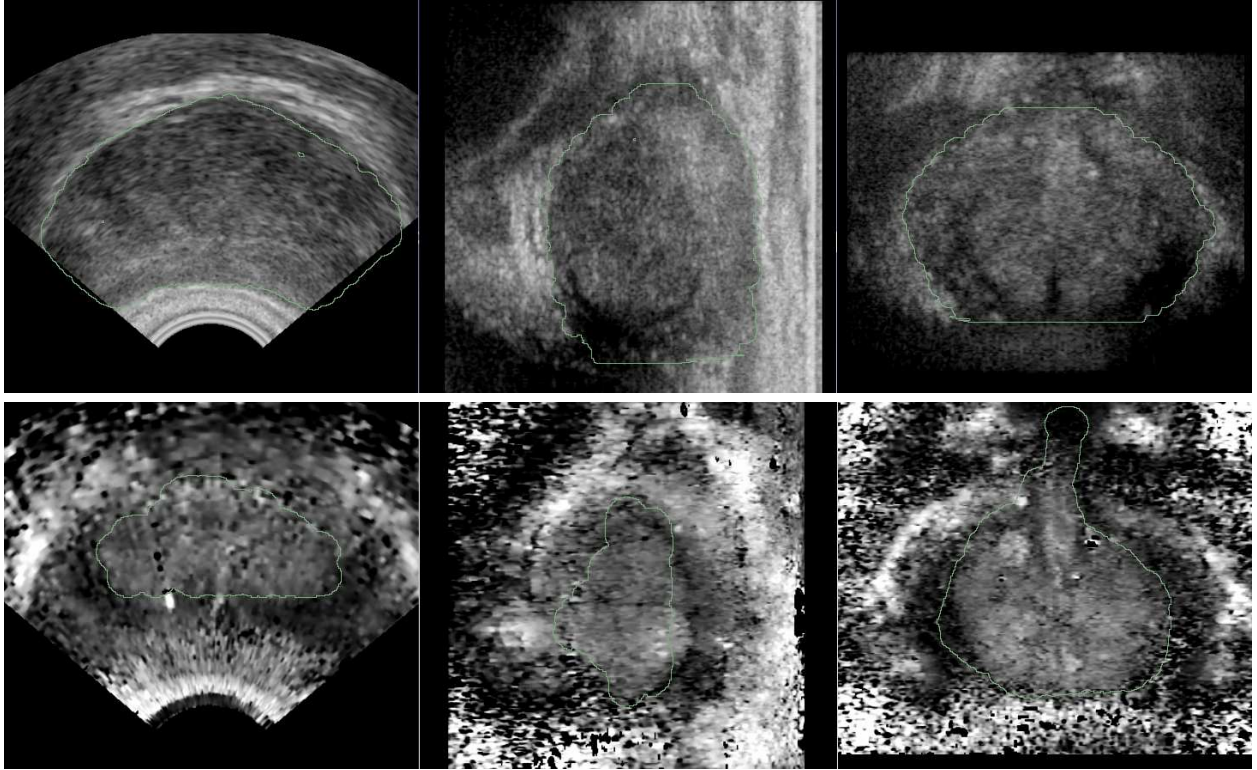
Representative B-mode (top row) and ARFI images (bottom row), with superimposed segmentation outlines of the capsule and CG, respectively, for the same study subject shown in Figure 2. The B-mode images were segmented in the axial view, using the hypoechoic border of the capsule. Notice that for large prostates, like the one shown in this figure, that the edges of the organ were not always captured in the imaging field-of-view. The CG in the ARFI images was typically segmented using the coronal view, which, especially in the presence of extensive BPH, can have a very characteristic, heterogeneous appearance. It should be noted that the coronal views in these ultrasound images are flipped 180° relative to the same images in Figure 2.
